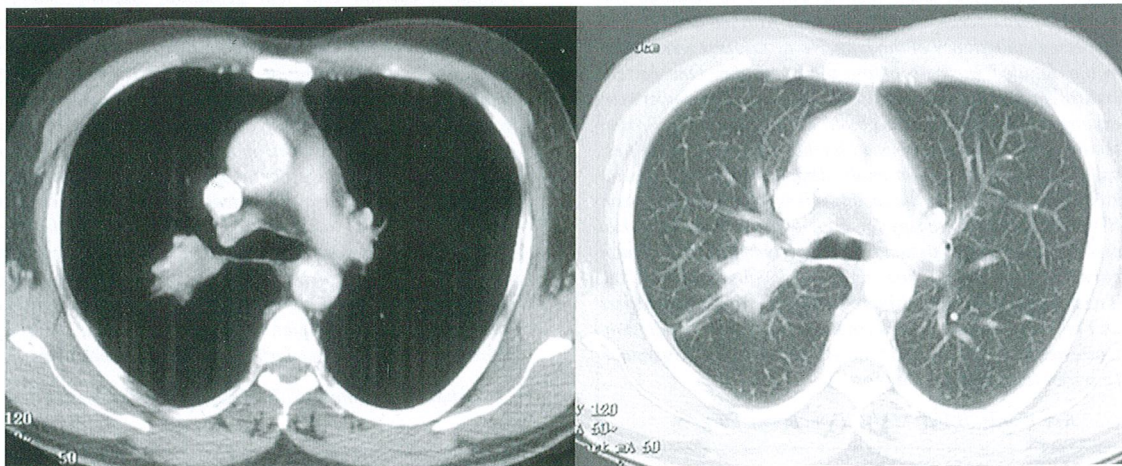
A,B: Computed tomographic sections of the first patient; a-mediastinal and b-parenchymatous window, showing the presence of a pulmonary mass.
